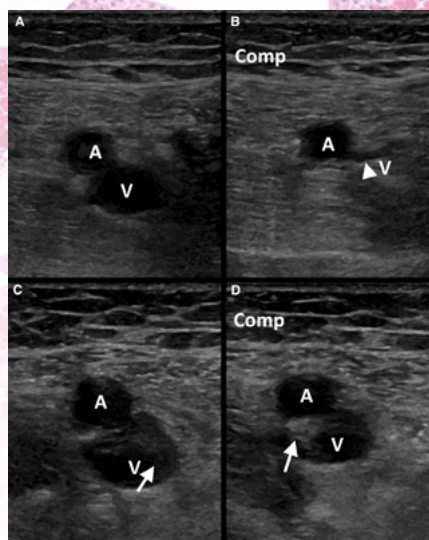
a and b. Normal popliteal vein without (a) and with (b) compression: Note that the vein (V) collapses (arrowhead in b) on compression by the ultrasound probe. c and d. Thrombosed of the popliteal vein without (c) and with (d) compression: Vein (V) does not collapse on compression. The thrombus (arrow in c and d) is easily seen. A is the popliteal artery.
